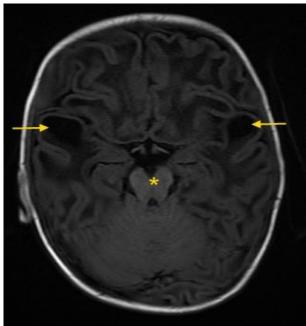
Axial T1 MRI brain showing bilateral temporal subcortical cysts (arrows) which are CSF intense. Note sparing of midbrain (asterisk)
